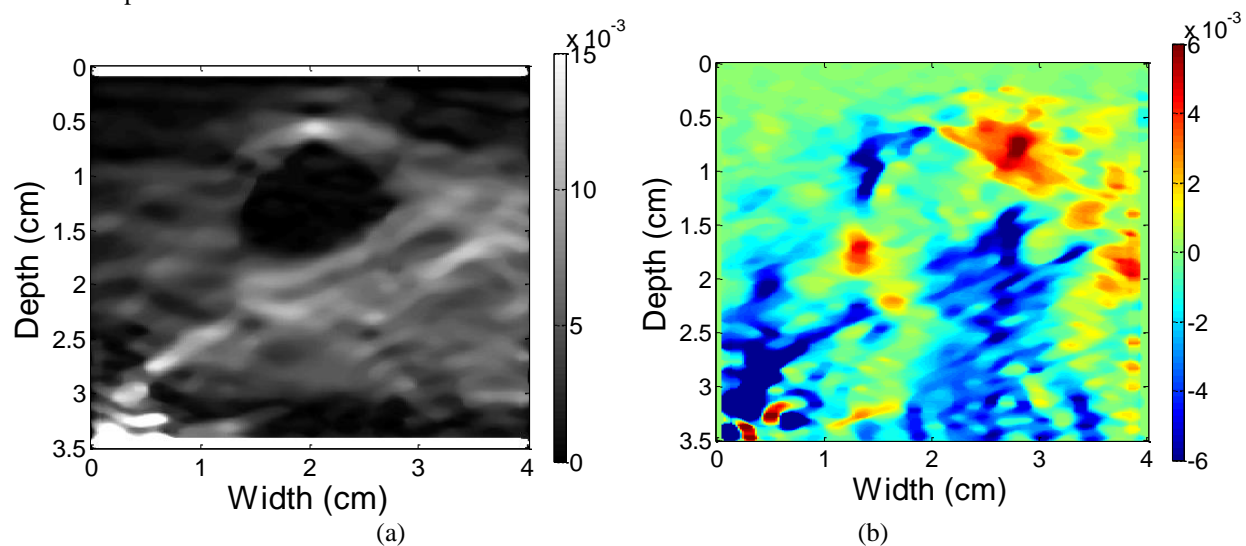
Ultrasound axial strain (a), and axial shear strain image obtained from RF data of a patient diagnosed with a fibroadenoma. The colorbar range is the same for all the axial strain and shear strain images, where a 1% strain is depicted as a 0.01 level.
